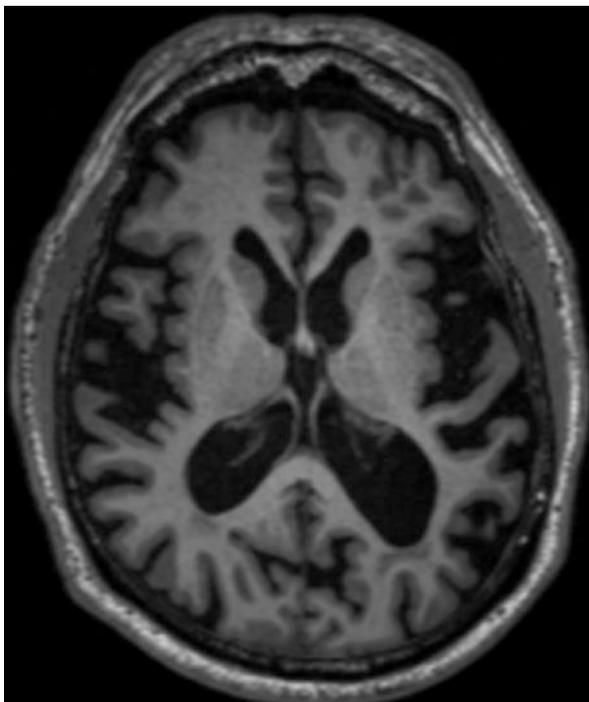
T1-MRI (*axial view*). Note selective posterior perisylvian atrophy, much worse on the left
